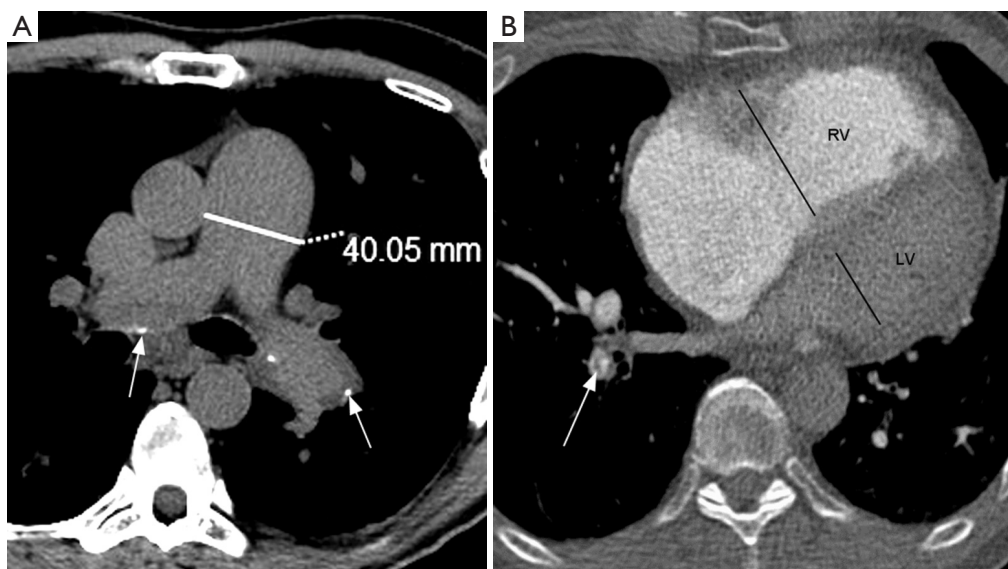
CT evaluation of pulmonary hypertension. (A) Noncontrast axial CT shows main pulmonary artery (MPA) of 40 mm and MPA/aorta ratio $> 1.1:1$, consistent with pulmonary hypertension. The absence of contrast facilitates the observation of chronic eccentric thrombi with mural calcification (arrows). Axial CT pulmonary angiography image (B) shows right ventricular enlargement (right-to-left ventricular ratio greater than 1:1). Webs noted in right lower lobe arteries, consistent with chronic pulmonary embolism (arrow).
